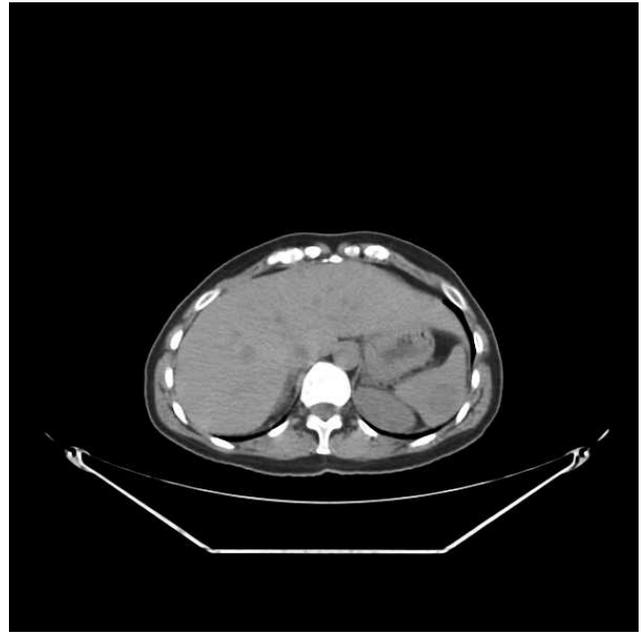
CT scan of splenic lesions.
